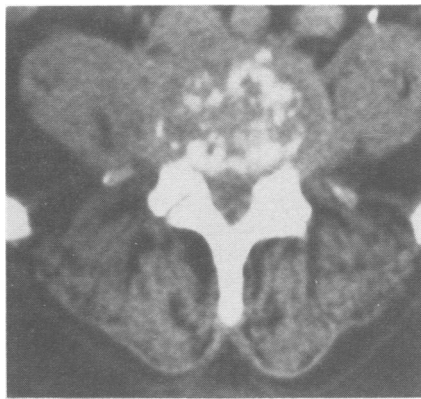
Computed tomography scan obtained three weeks after admission to hospital showing multiple bone erosions of the superior vertebral end plate of L5 with swelling of the surrounding soft tissues.
